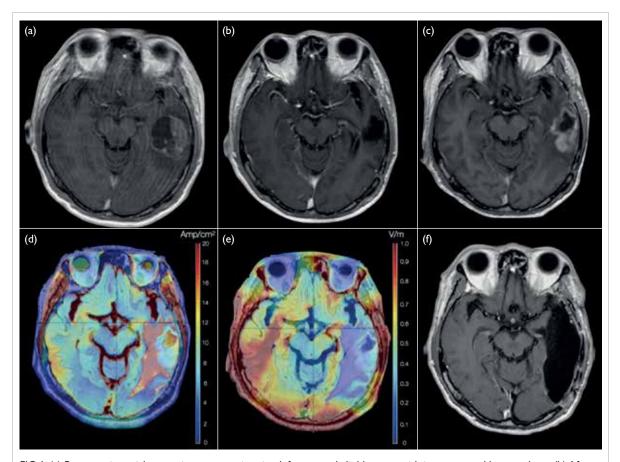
(a) Preoperative axial magnetic resonance imaging: left temporal glioblastoma with intratumoural haemorrhage. (b) After concomitant temozolomide chemoradiotherapy and 5 months of tumour-treating fields (TTF). (c) First disease progression after I2 months of TTF. (d, e) TTF current density (Amp/cm²) and electric field intensity (V/cm) maps revealing increased electromotive force delivery to the peritumoural region after gross total resection of the patient's first tumour recurrence. (f) No evidence of residual tumour 3 years after initial diagnosis and 30 months of TTF.
